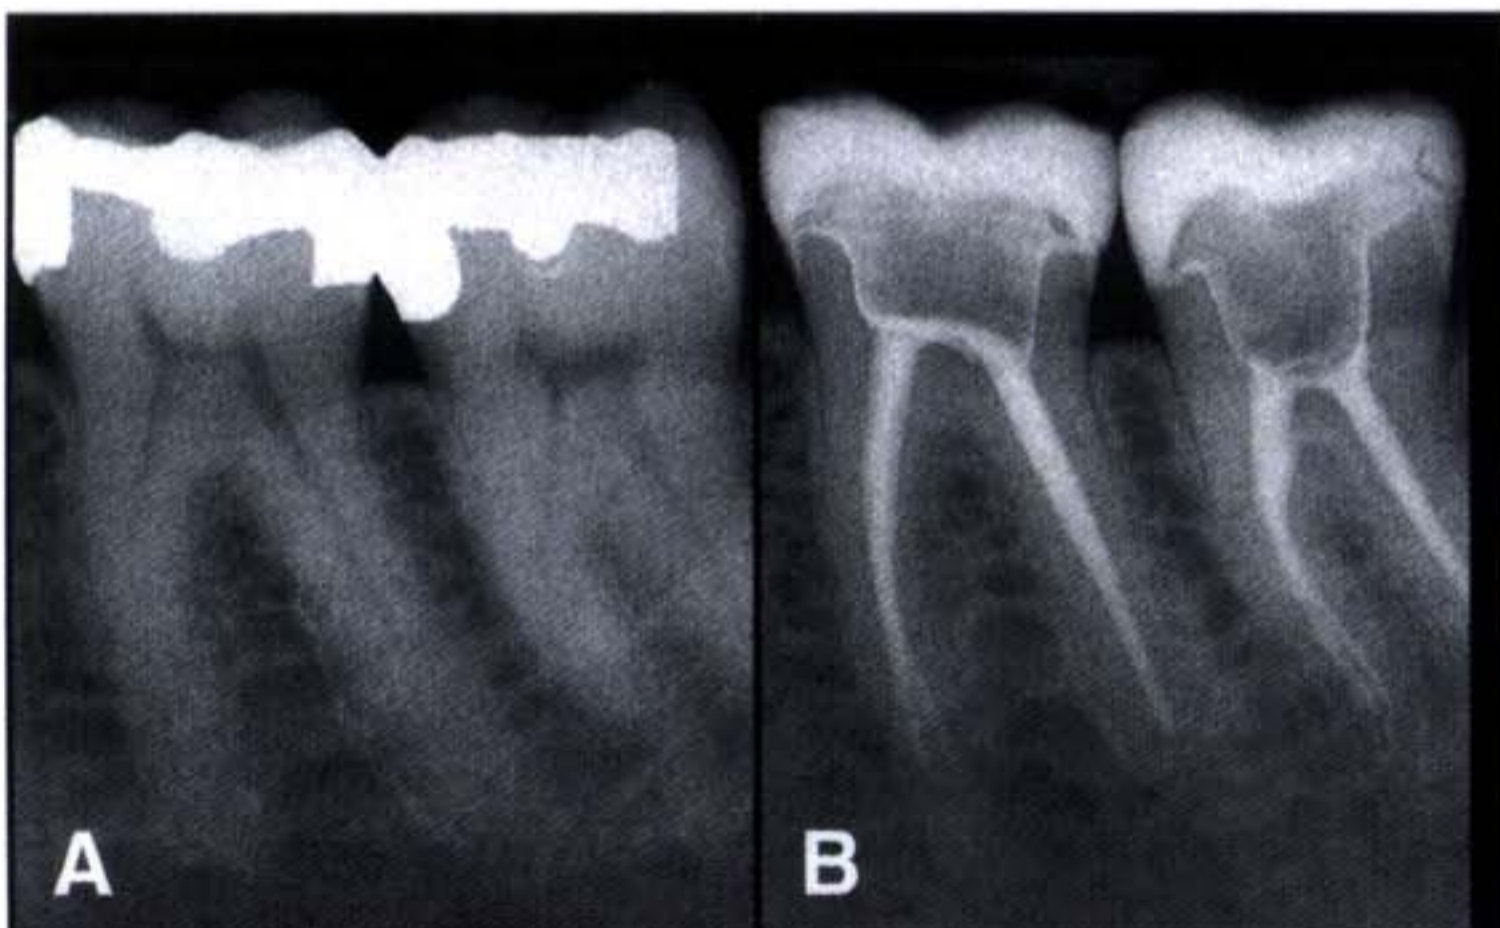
Preoperative radiograph prior to endodontic and prosthetic treatment. Figure 6B. Postoperative radiograph depicts integration of single-unit crown and core.
